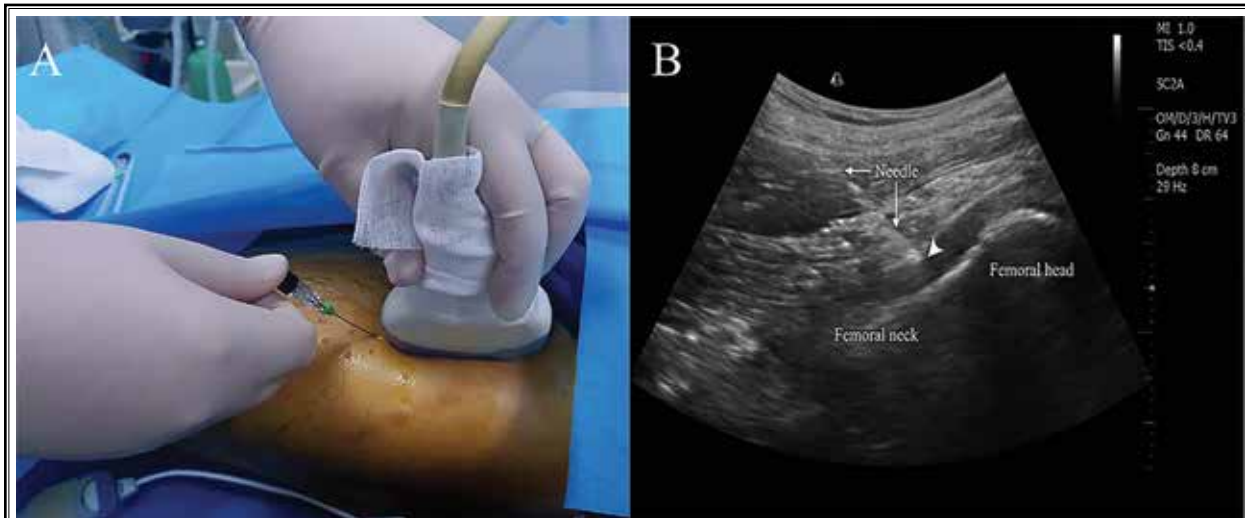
Ultrasound-guided ozone intrarticular hip injection for ONFH.
